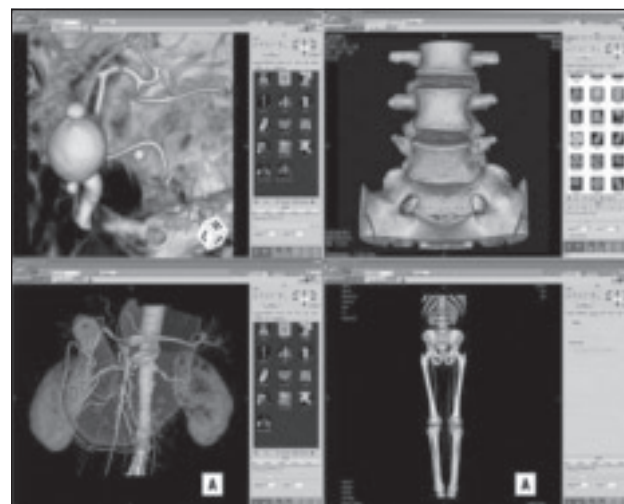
Four screenshots showing a cerebral aneurysm (top left), a lumbar spine with Parr's fracture (top right), a computed tomography angiogram of the upper abdominal vasculature and stomach (bottom left) and a computed tomography angiogram run-off examination from the thorax to the ankles. (AquariusNET Client software image courtesy of TeraRecon, Inc.)
